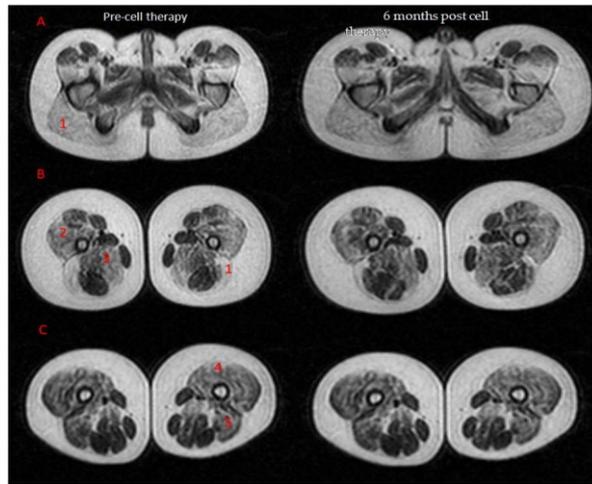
T1W axial MR images of (A) pelvic girdle, (B) upper thigh, and (C) lower thigh.
